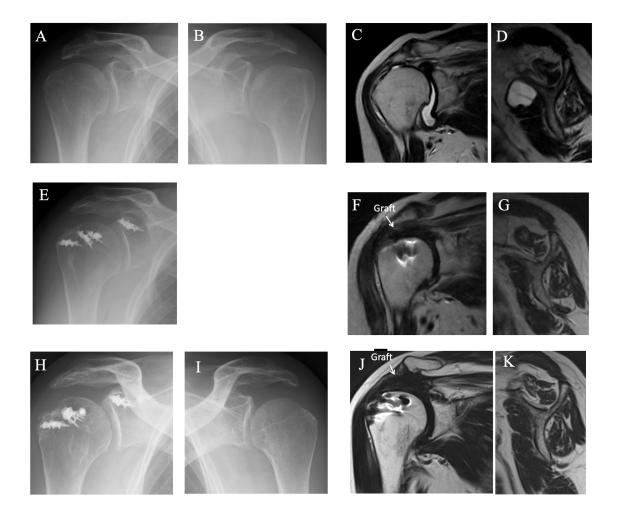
X-ray and T2-weighted MRI findings before and after arthroscopic SCR. All images are from the same patient. (A) X-ray of the affected shoulder before surgery. AHD 4 mm, Hamada grade 2. (B) X-ray of the unaffected shoulder before surgery. AHD 10 mm, Hamada grade 1. (C) Coronal MRI before surgery. The torn supraspinatus tendon is severely retracted, and the supraspinatus muscle is severely atrophied and infiltrated with fat. (D) Sagittal MRI before surgery. Goutallier grade 4 in the supraspinatus muscle. (E) X-ray at 1 year after SCR. AHD 11 mm, Hamada grade 1. (F) Coronal MRI at 1 year after SCR. Healed graft shows isointensity. (F) Sagittal MRI at 1 year after SCR. Goutallier grade 4 in the supraspinatus muscle. (G) X-ray of the affected shoulder at 10 years after SCR. AHD 11 mm, Hamada grade 1. (I) Coronal MRI at 10 years after SCR. Healed graft shows low-intensity signal. (J) Sagittal MRI at 10 years after SCR. Goutallier grade 4 in the supraspinatus muscle.
